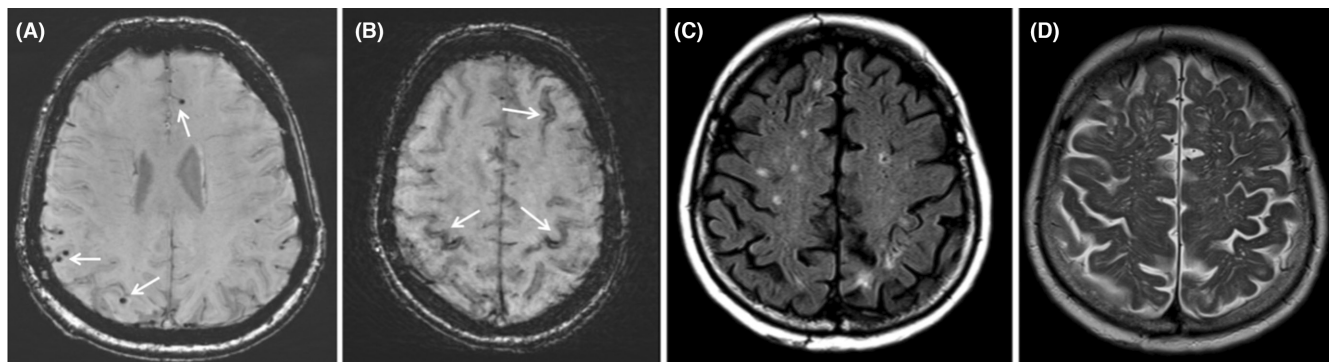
MRI markers of ICH recurrence. (A) Multiple lobar microbleeds. (B) Multifocal cortical superficial siderosis. (C) White matter hyperintensities with a «spot-like» pattern. (D) Enlarged perivascular spaces in the centrum semiovalis. Abbreviations: ICH, intracerebral haemorrhage, MRI, magnetic resonance imaging.
